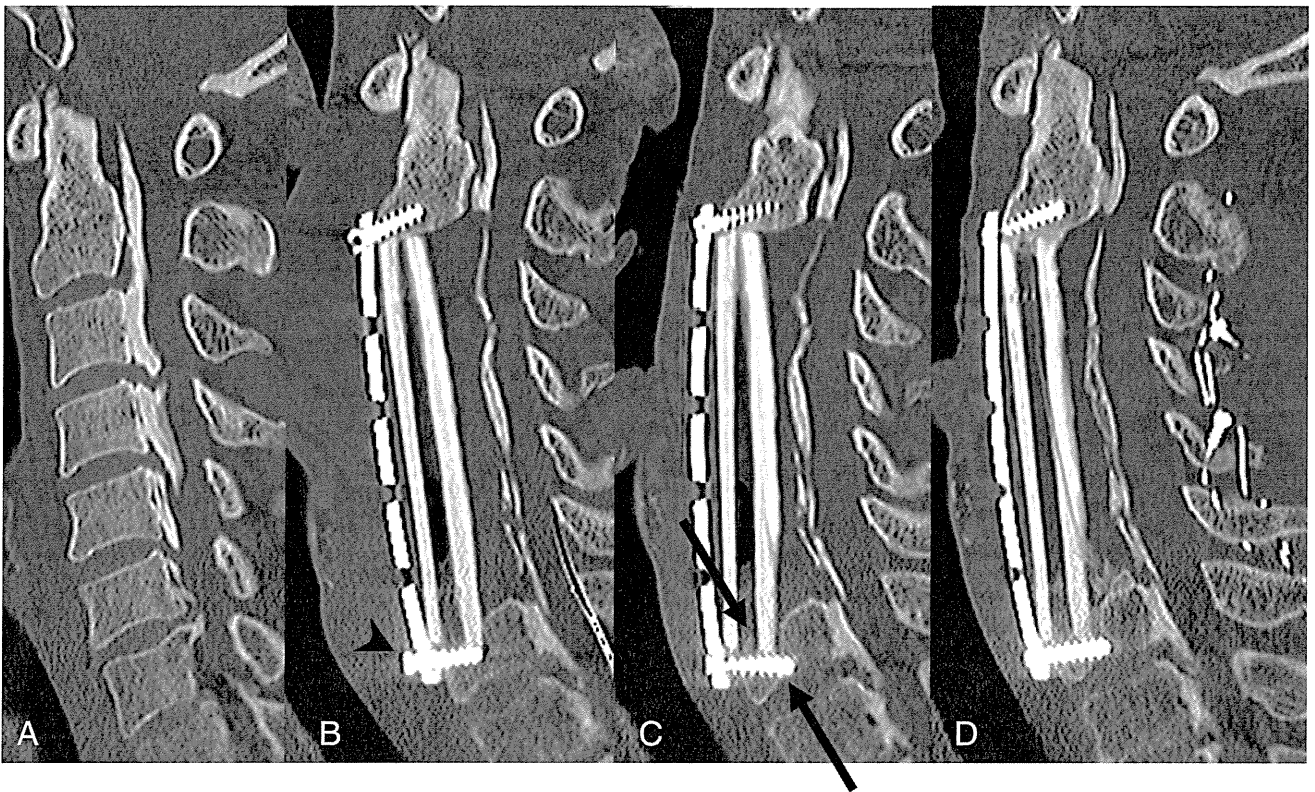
Preoperative radiograph of a 51-year-old man shows mixed-type OPLL with a slight lordosis (A). Postoperative scan taken 3 weeks after the surgery revealed screw pullout (arrow head) (B). Note cervical lordosis seemed to increase after the surgery. The screw was retightened, but graft subsidence and C7 fracture occurred (arrows) (C). After *in situ* spinous process wiring, the degree of the patient’s cervical lordosis decreased. However, solid fusion was observed (D).
